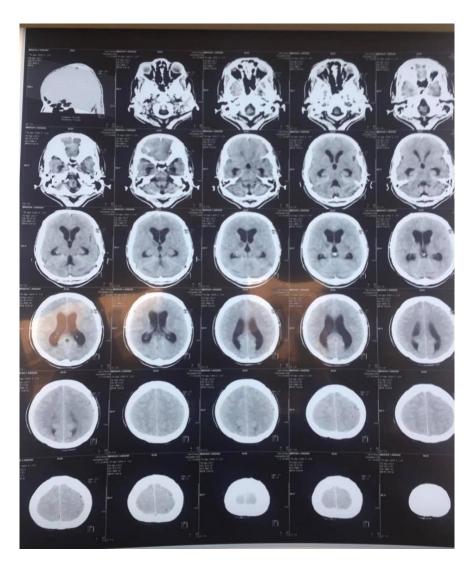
Axial section of the CT- Scan of brain showing dilated ventricles (hydrocephalus) with right thalamic infarction.
